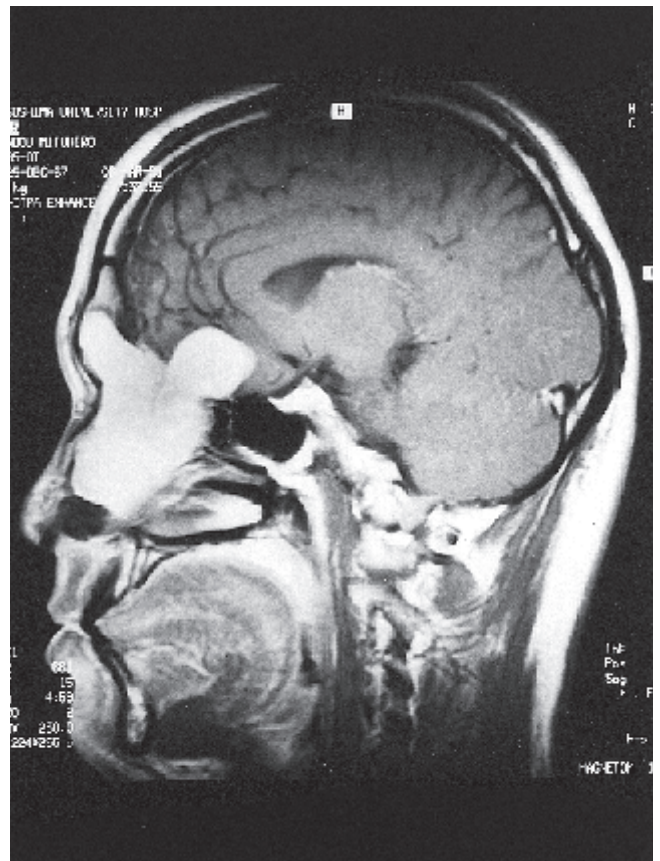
Sagittal MR image with gadolinium enhancement showing a tumour of high intensity, which extends from the nasal cavity to the ethmoid and frontal sinuses and to the cranium.
